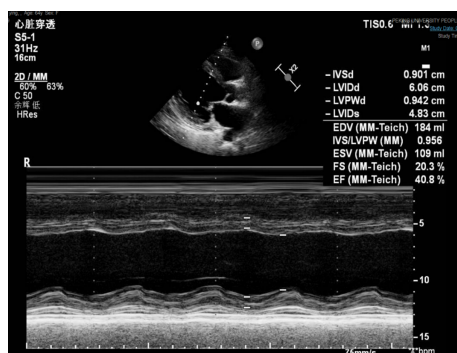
Echocardiography 2 d after admission. Left ventricular systolic function improved after calcium supplementation. The ejection fraction was 40.80%.
